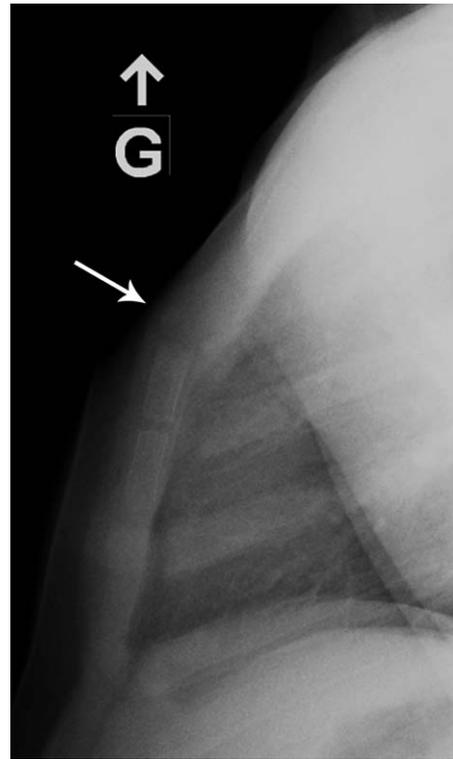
Follow-up sternal radiograph 10 months after initial presentation shows partial remodeling of the first sternal segment (arrow).
